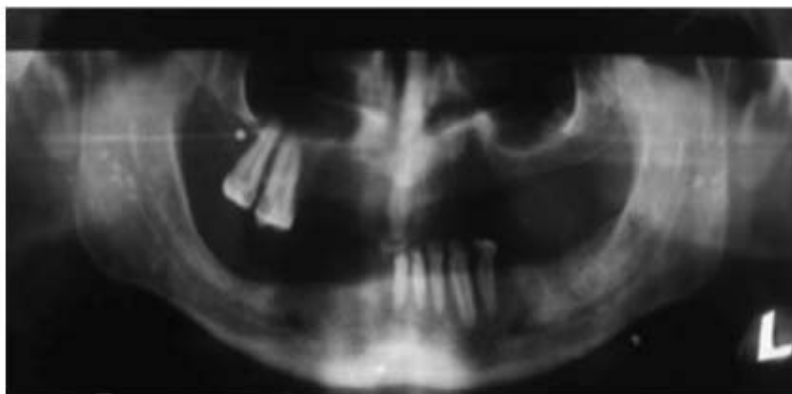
Orthopantomogram of an inhomogeneous radiopaque lesion.
